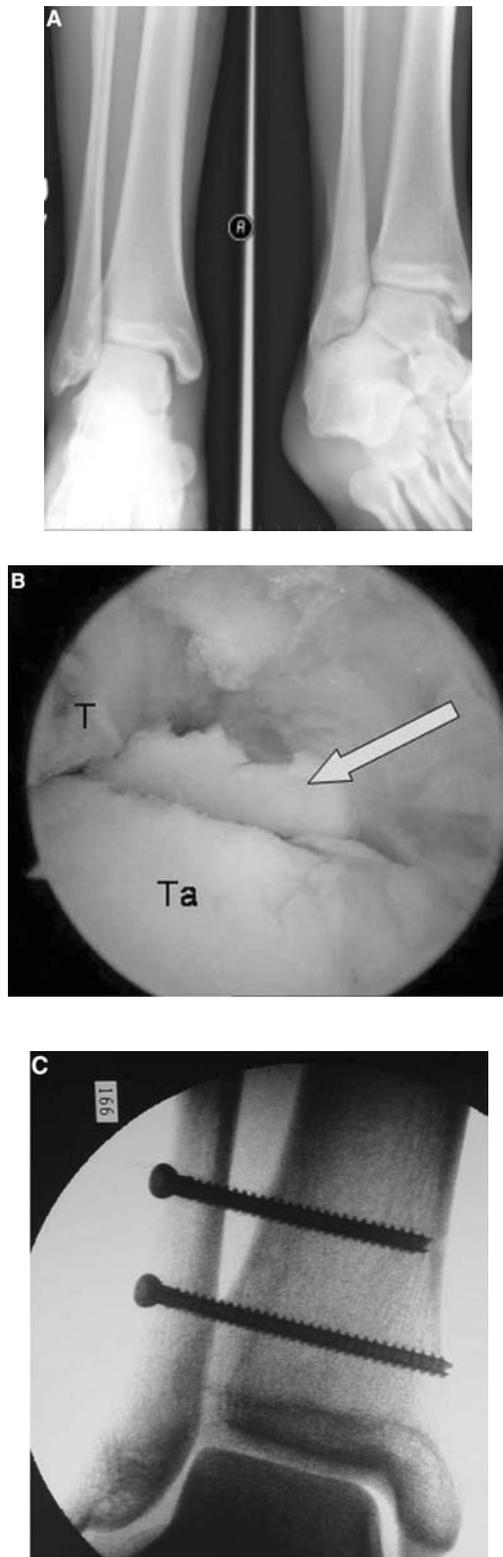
A, anteroposterior and mortise views demonstrate a complete disruption of the syndesmosis. B, arthroscopic examination revealed widening of the syndesmosis as pictured in Figure 6 and a chondral flap (arrow). C, radiographic view demonstrates reduction and stabilization with 2 screws. T, tibia; Ta, talus.
